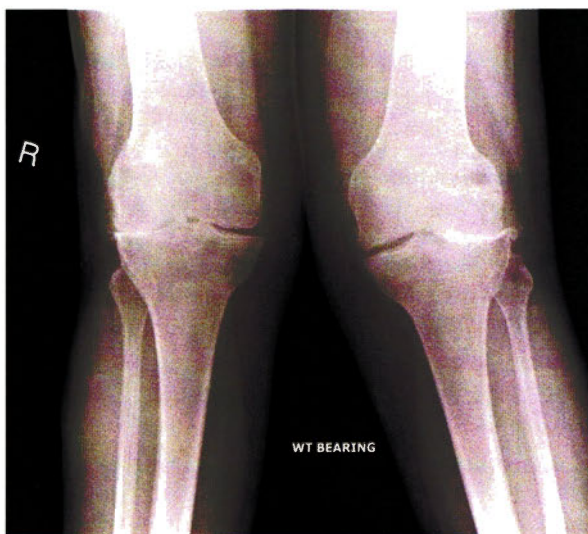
Standing radiographs of the knees showing severe OA with loss of joint spaces
